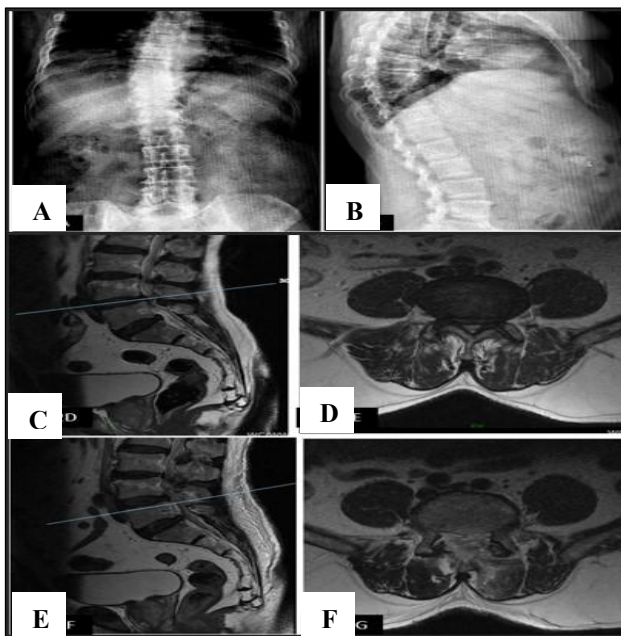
Case Example 2: 72-year-old male with lumbar canal stenosis at L4-L5, presenting with left lower limb radiculopathy. (A and B) Show anteroposterior (AP), lateral x-rays, (C and D) display sagittal and axial T2-weighted MRI images demonstrating significant neural compression at L4-L5, (E and F) represent postoperative MRI images showing satisfactory decompression.
